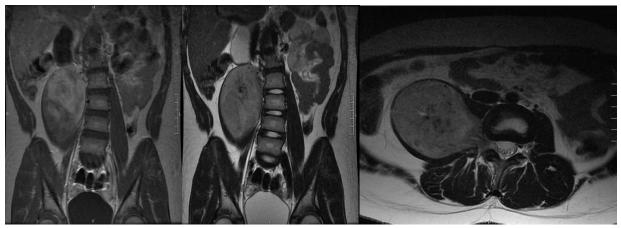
MRI of the spine.
